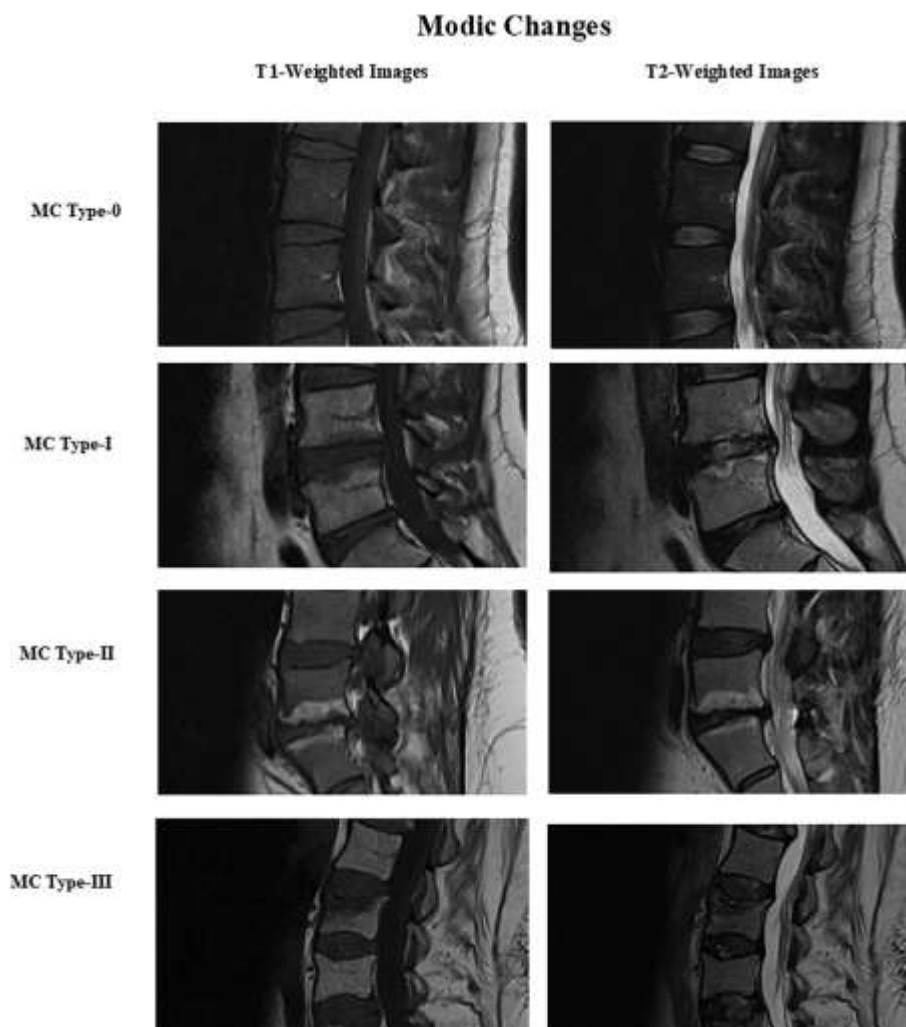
The three types of Modic changes compared with normal (also called Modic-0) represent endplate and vertebral bone marrow changes detected by MRI T1-weighted and T2-weighted images. The bone marrow edema (hypointense on T1-weighted and hyperintense on T2-weighted MRI imaging). This is followed by the replacement of red bone marrow with yellow fatty bone (hyperintense both in T1 and T2 weighted images) in Modic type-II changes and subsequently by sclerosis (hypointense in both T1 and T2 images) in Modic type-III changes, usually seen in older ages [44].
